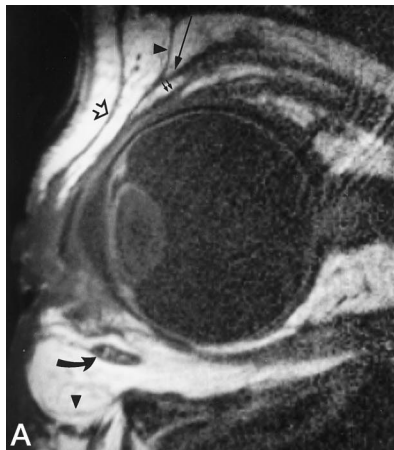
A, T1-weighted sagittal MR image (600/20/2) of the left orbit of a 69-year-old patient with malignant corpus ciliare melanoma (not shown). Note the bulging lower lid due to the pressure of the intraorbital fat. Arrowheads indicate septum orbitale; open arrow, orbicularis oculi muscle; long arrow, levator aponeurosis; small arrows, levator tarsi superior (Müller's) muscle; and curved arrow, inferior oblique muscle.
